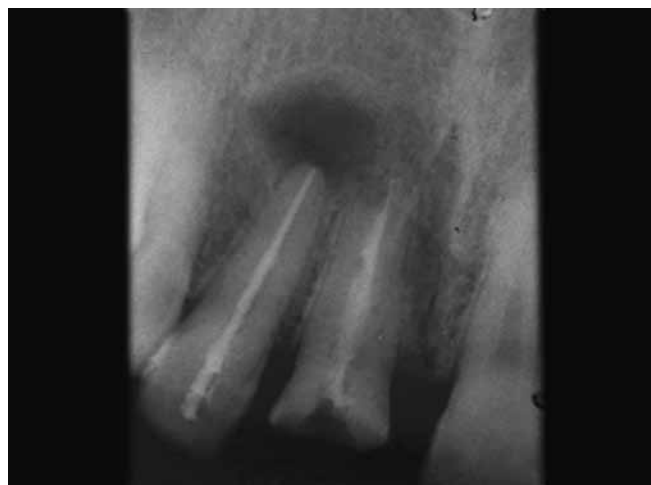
Preoperative radiograph showing poor endodontic treatment done in upper left maxillary central and lateral incisors
